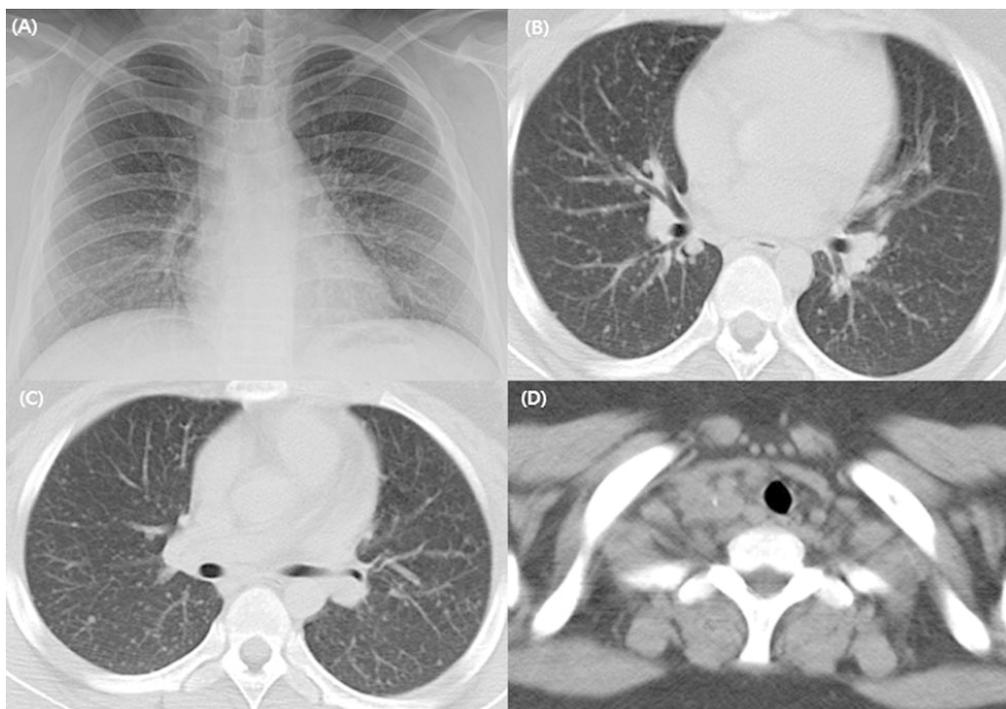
On the chest radiography, multiple tiny nodules were observed (A). His chest tomography showed small-sized calcifications in the right thyroid gland (B). Numerous tiny nodular lesions on both lungs were observed in both lungs (C and D).
